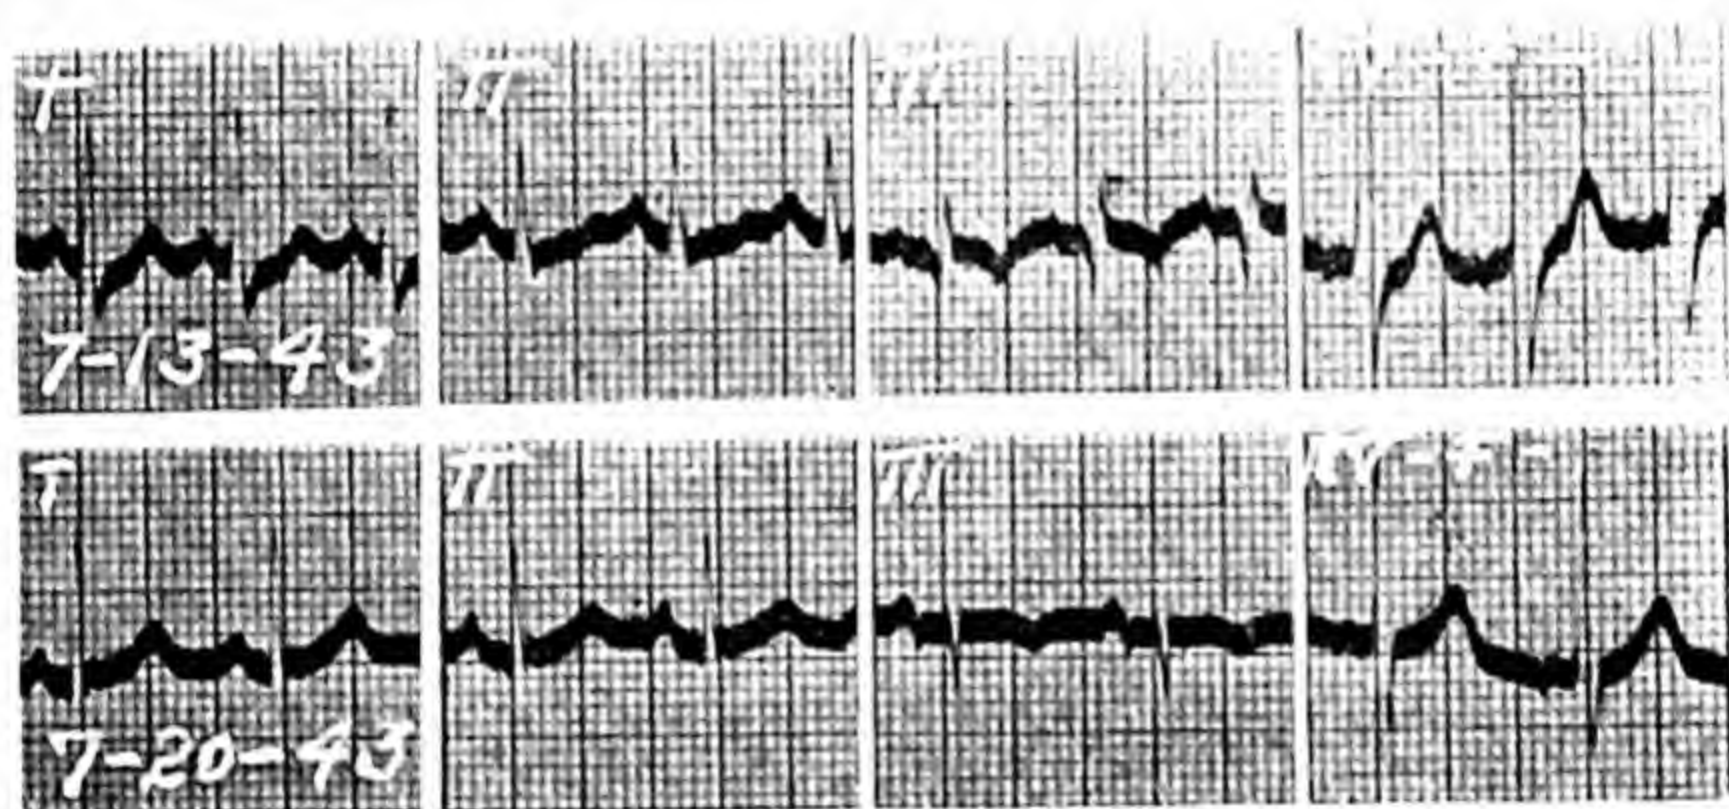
Abnormal Form of Ventricular Complex (Pulmonary Embolism) The patient was a man forty-two years old, who was well except for an inguinal hernia. His heart was normal. Operation was performed on July 1, 1943, under spinal anesthesia. He was doing well when on July 13, 1943, while on a bed pan, he had sudden pain in the left anterior chest, dyspnea, tachycardia and apprehension. The pulse rate was 140, respiration 28, blood pressure 180 systolic and 80 diastolic. His legs showed nothing abnormal. x-Ray showed slightly cloudy left base and elevated left diaphragm. On July 14, 1943, bilateral ligation of the femoral veins was performed. The patient ran a temperature of 101° to 102° F. for five days and recovered. The first tracings show changes indicative of acute cor pulmonale, *i.e.*, an  $S_1$ , a  $Q_3$ , a depressed  $S-T_1$ , an elevated  $S-T_3$ , and an inverted  $T_3$ . Note the disappearance of these changes in the second tracing.
